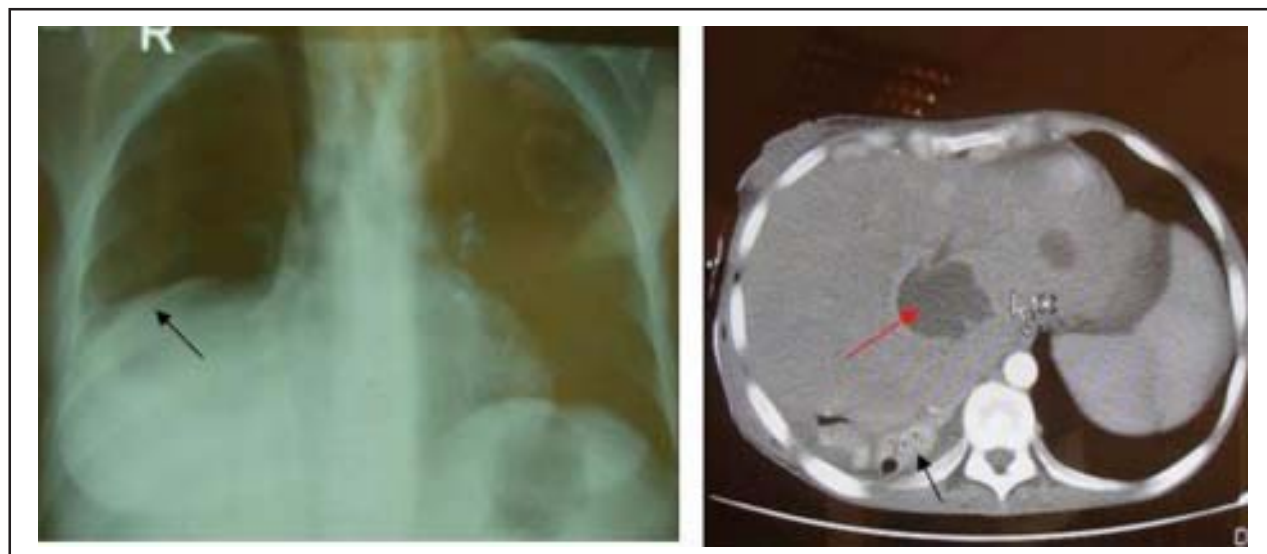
Chest x ray (A) and CT scan (B) showing right lower lobe subsegmental collapsed consolidation (black arrows), and large intrahepatic collection (Fig 1, B red arrow).
